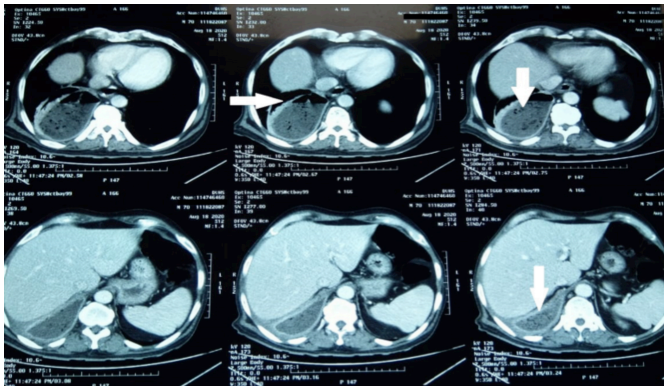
CT scan chest with contrast showing a large outpouching seen arising from right posteromedial wall of distal dorsal esophagus starting at subcarinal level with a neck of 0.9 cm, containing food particles and measuring 15.6 × 7.6 × 7.6 cm causing consolidation and collapse of adjacent medial and posterior segments of the right lung.
